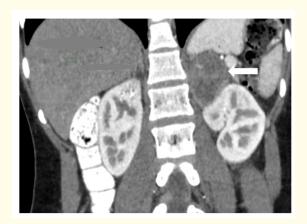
Computed tomography scan of left adrenal cystic mass.
